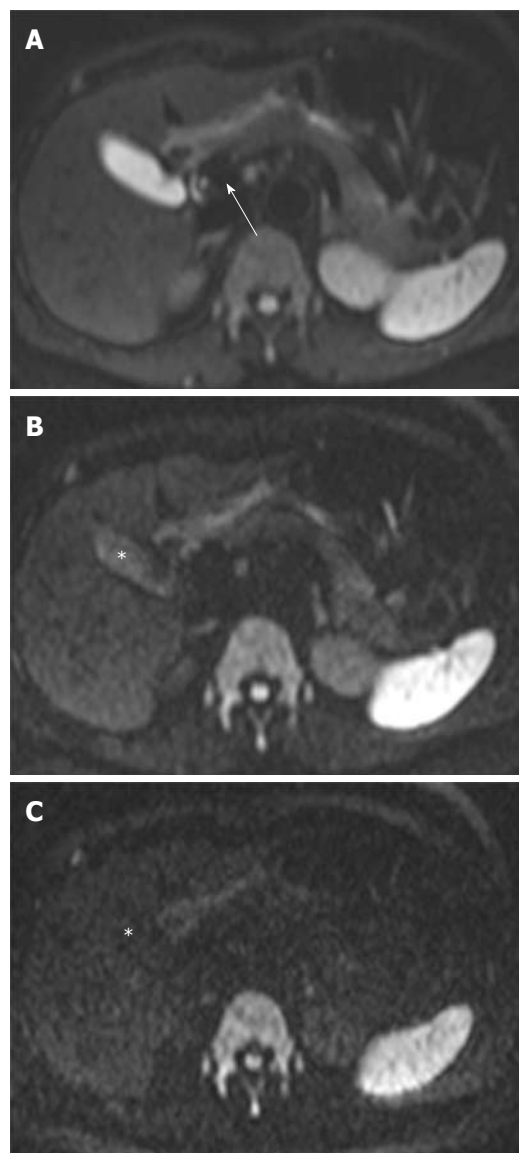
DWI of the normal liver, pancreas, and biliary tract. A: DWI at $b = 50 \text{ s/mm}^2$ shows that the liver is hypointense compared to the kidney and spleen, and isointense compared to the pancreas; there is a signal void within the portal vein (arrow). DWI using low b values results in decreasing signals of fast motion of water molecules, such as that occurring within vessels. Such images are referred to as black-blood images; B: DWI at $b = 500 \text{ s/mm}^2$ shows that the signal intensity of bile is decreased (asterisk) and the wall of the gallbladder is not identified. The liver is isointense compared to the pancreas; C: DWI at $b = 1000 \text{ s/mm}^2$ shows a significant reduction in the signal intensity of bile in the gallbladder (asterisk). DWI: Diffusion-weighted magnetic resonance imaging.
